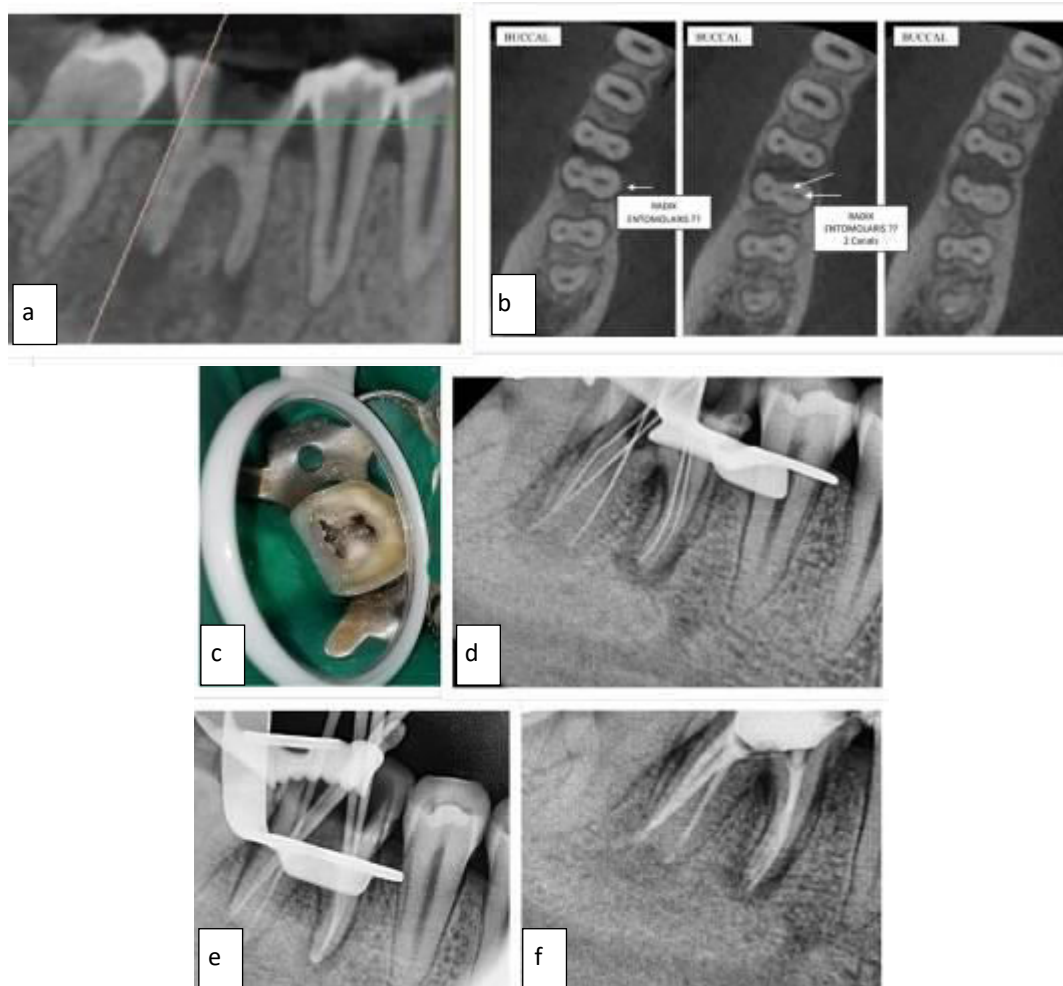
(a) CBCT cross section irt #46 (b) axial section irt # 46 (c) Clinical photograph (d) Working length radiograph irt # 46 (e) Mastercone radiograph irt # 46 (f) Postoperative radiograph irt # 46
